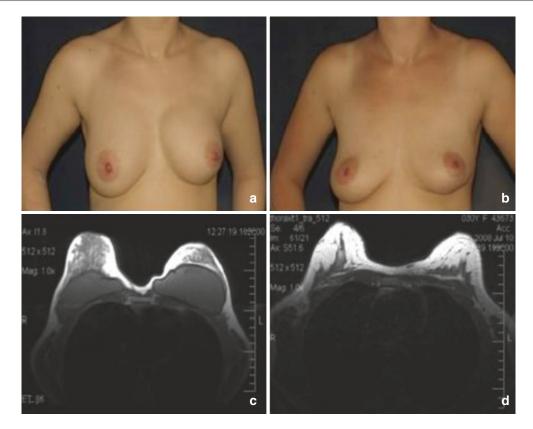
(a–d) Capsular fibrosis (left) after mammary augmentation through the insertion of silicone implants (a, c) and 6 months after the BEAULI procedure (b, d), respectively, in the clinical aspect and in the MRI
